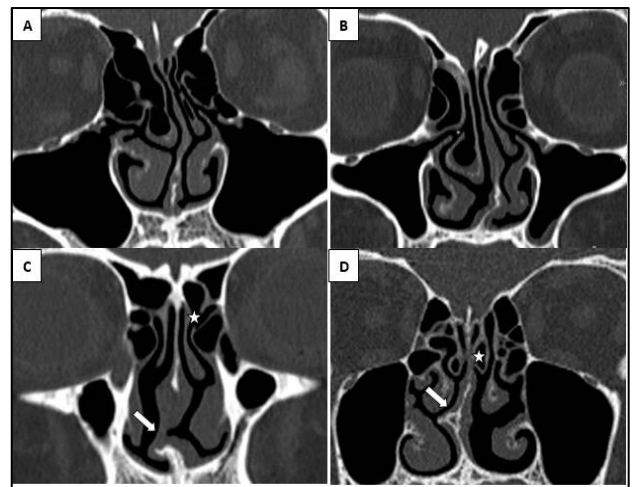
(A) Deviated nasal septum - CT scan shows single curvature involving the whole septum with convexity towards left. Associated asymmetry of the uncinate processes seen. (B) Focal septal deviation - focal curvature of lower third of the septum towards left. Both the above types of deviations are associated with right sided middle turbinate concha bullosa and hypertrophied inferior turbinate. (C) Deformed chondro-vomer junction shows dislocation of septal cartilage towards right (←). Also note bilateral prominent agger nasi cells located inferior and lateral to the nasofrontal recess (*) and above the upper ends of nasolacrimal ducts. (D) Septal spur (←) on the right. Also note bilateral pneumatized superior turbinates (*).
